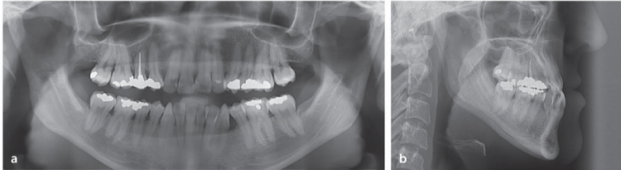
(a and b) Initial panoramic and cephalometric radiographs.
